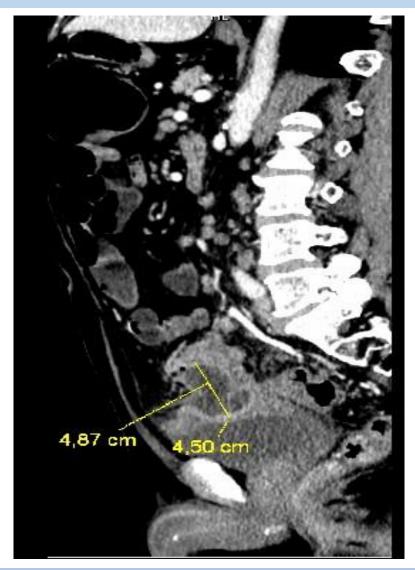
Sagittal section of abdominopelvic CT, with abscess measuring 4.87 x 4.5 cm
